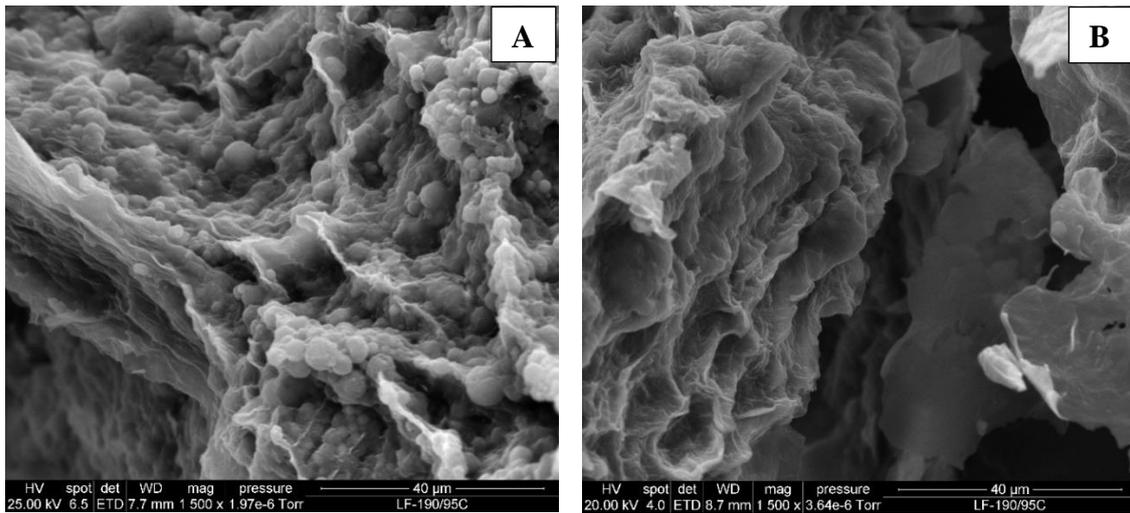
SEM images of spent HSMs of alkaline pH cycling alone (A) and alkaline pH cycling treatment combined with ultrasound (B).
